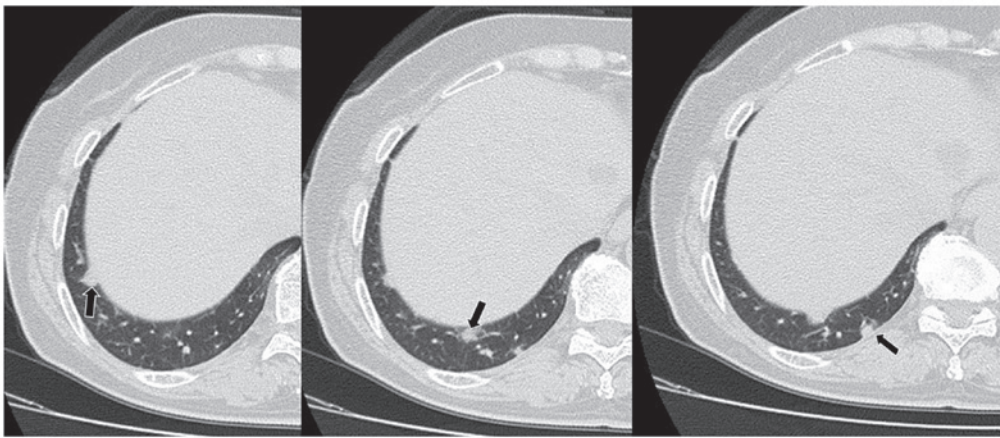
Follow-up chest computed tomography scan, performed 24 months after the surgery, detected pulmonary metastatic tumors ≤ 15 mm in the right lung (arrows).
